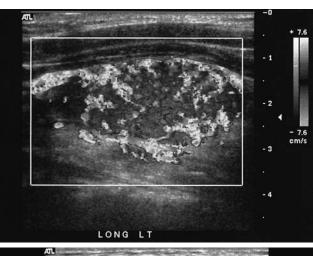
Longitudinal sonograms of the thyroid gland.
